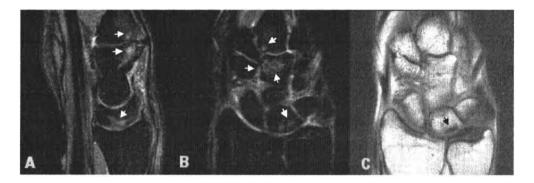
Case 4 right wrist MR images.
